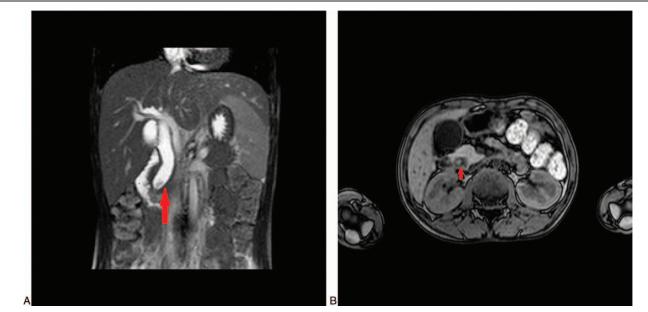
Magnetic resonance imaging performed 10 days after admission of the 14-year-old male patient. (A) Dilatation of the extrahepatic bile duct (arrow). (B) Soft-tissue mass protruding into the lumen of the duodenum.
